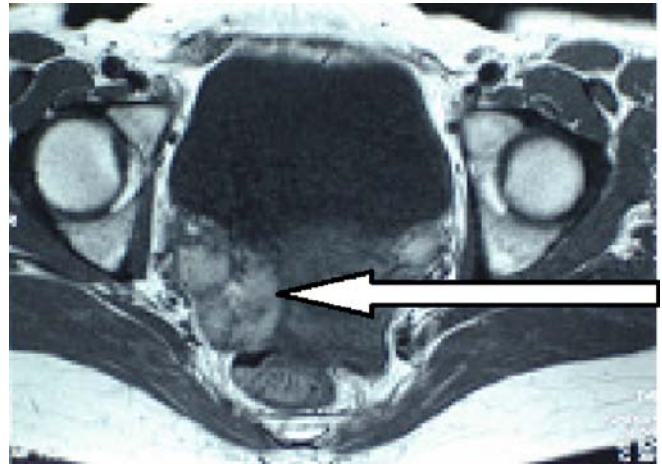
Magnetic resonance imaging: endometriosis implant on the right ovary (*white arrow*)
